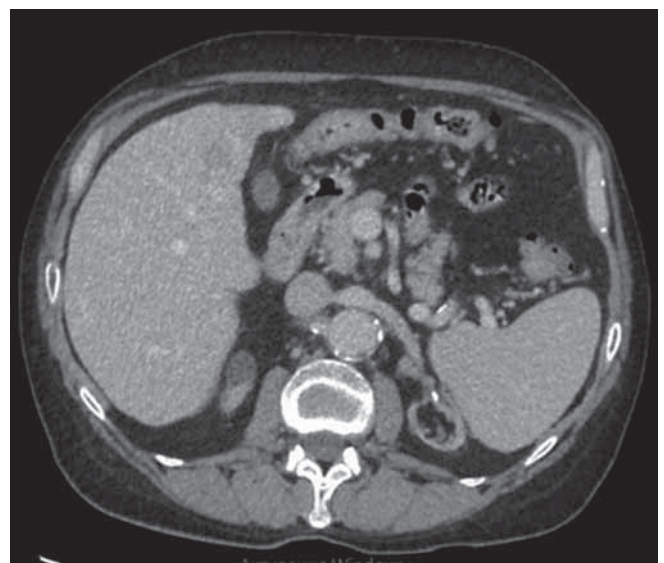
Contrast-enhanced abdominal CT scan. Signs of liver cirrhosis, hepatocellular carcinoma, portal hypertension
